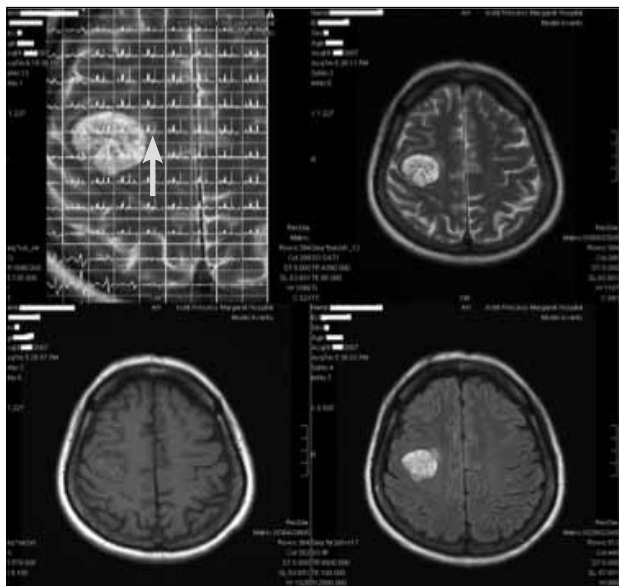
Chemical shift imaging (CSI), selected axial T2-weighted, fluid-attenuated inversion recovery with contrast and T1 with contrast images of a female elderly patient with renal cell carcinoma. The choline/N-acetyl-aspartate ratio in the peri-tumoural cerebral oedema is <1. Arrowed is the immediate peri-tumoural cerebral oedema and its corresponding CSI is used as interpretation.
